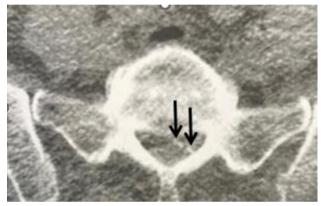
Lumbosacral CT scan for post-zone therapy. The findings appear unchanged compared to the previous check, confirming the picture of calcific epiduritis (arrows)
